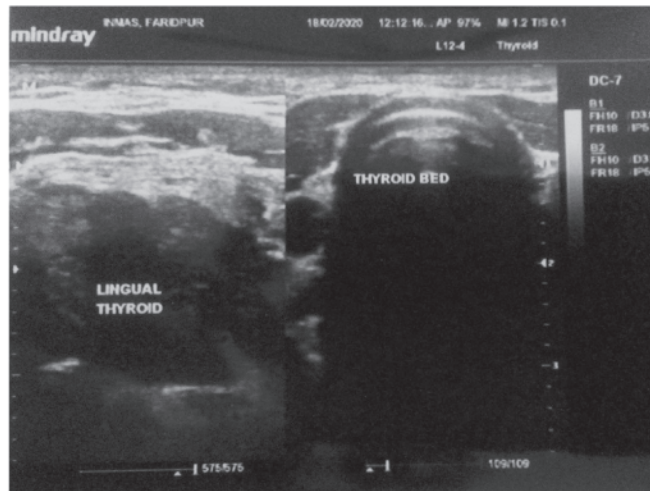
Ultrasound examination showing empty thyroid bed and ectopic thyroid tissue in lingual region
